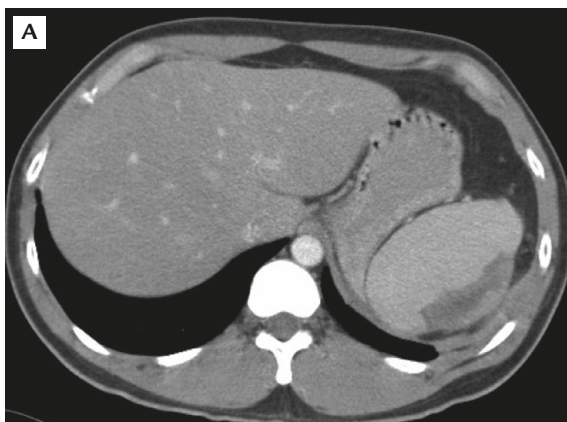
Abdominal computed tomography shows a large blood-containing fluid space measuring  $15.0 \times 13.0 \times 9.5\text{ cm}$ . The lesion is confined to the splenic capsule and attached to the pancreatic tail.
